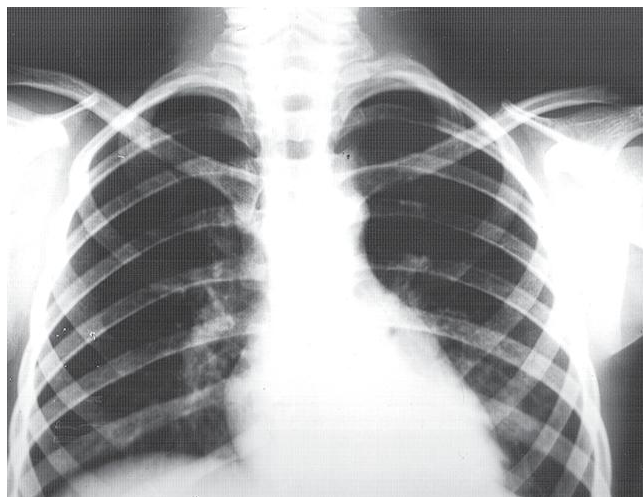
X-ray of child L. from 09/10/23
